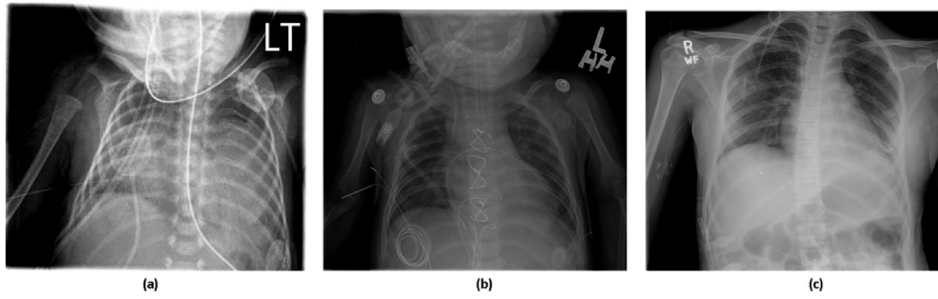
Pediatric chest radiographs demonstrating readers' assessment of image quality as (a) poor, (b) acceptable and (c) excellent.
